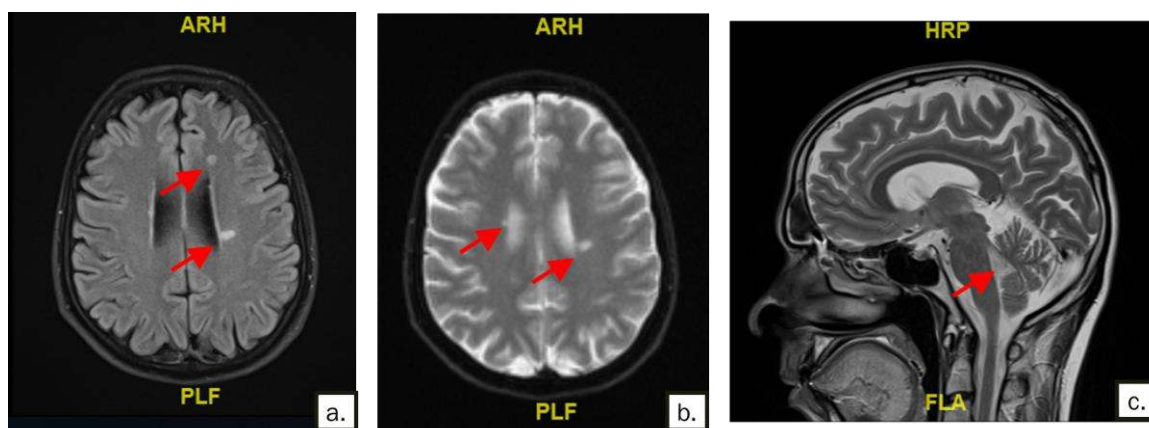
Cranial MRI sections showing hyperintense lesions (a and b) and relative atrophy of cerebral and cerebellar regions (c) of the index case of Family 4 (E.G.)
